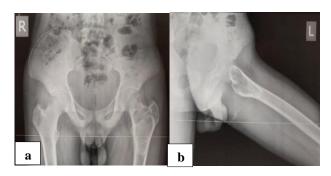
AP and lateral radiographs showing lytic lesion in left proximal femur with sclerotic margin.
